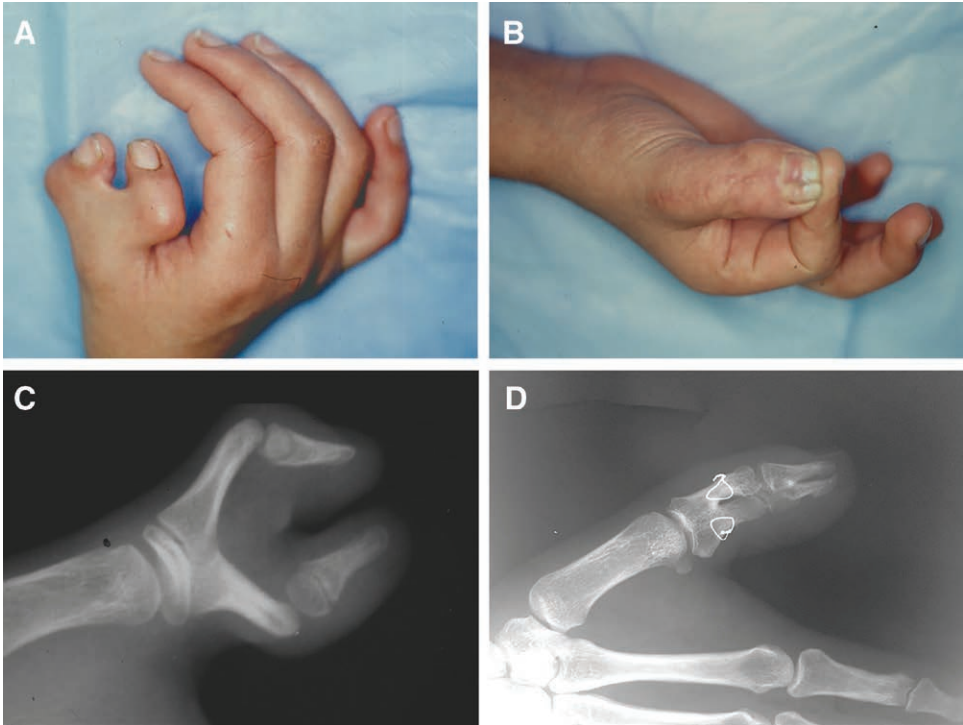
Case 2 with type III duplication. A, Preoperative appearance, (B) final postoperative appearance, (C) preoperative X-ray, and (D) final postoperative X-ray. There was bony union at the distal and proximal phalanges.
